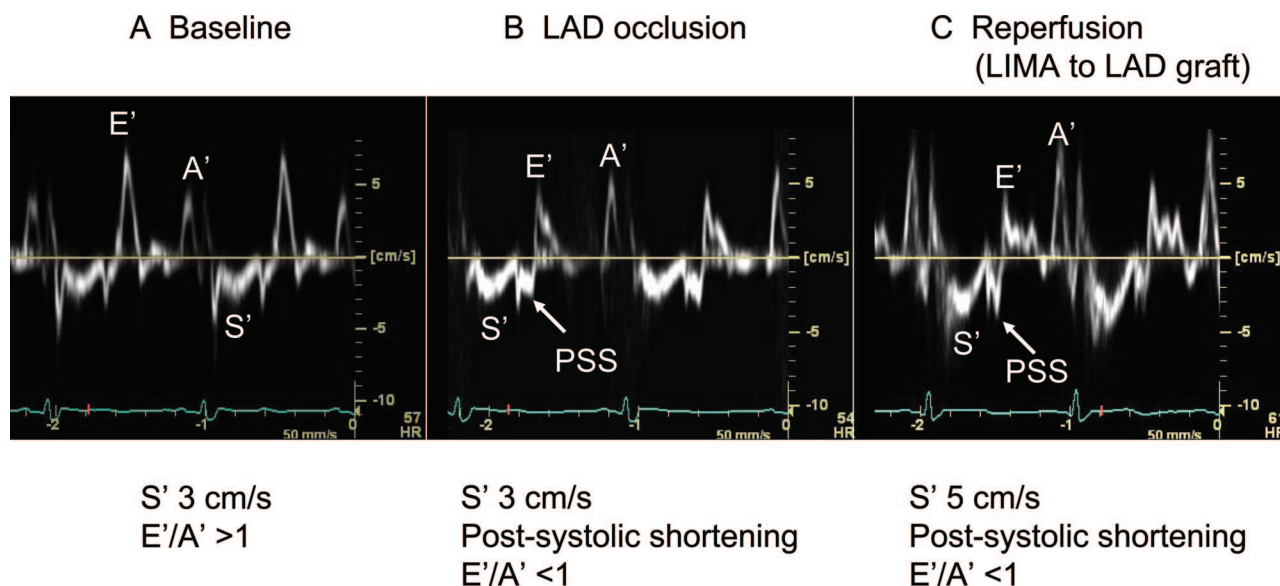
Ischemia detection with spectral Doppler tissue imaging in a patient undergoing off-pump coronary artery bypass surgery. (A) Baseline myocardial velocities. (B) Occlusion of the left anterior descending (LAD) coronary artery caused appearance of postsystolic shortening (PSS) and reversal of E'/A' ratio. PSS is in the same direction with S' . (C) After reperfusion of the left internal mammary artery (LIMA) to LAD graft, persistence of PSS is characteristic of stunned myocardium. S' is increased. Recordings were made from basal anterolateral left ventricular wall (mid-esophageal four chamber view). S' = systolic; E' = early diastolic; A' = late diastolic myocardial velocities.
